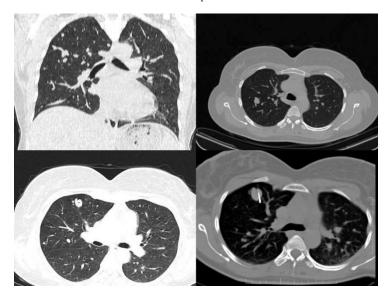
Non contrast CT chest axial lung and mediastinal window and coronal lung window showed multiple variable sized lobulated soft tissue
